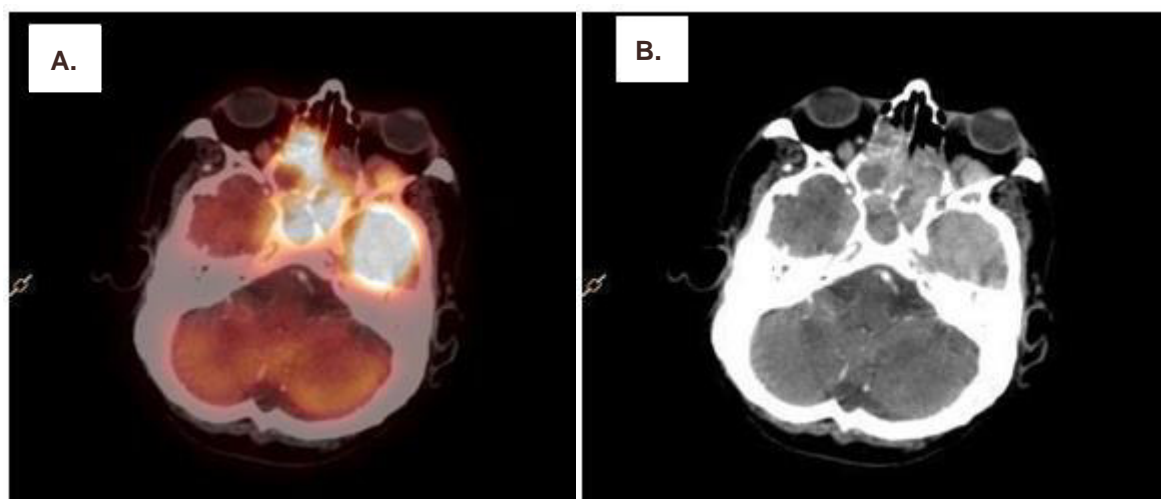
(A, B) shows the intracranial extension of the mass, which is intensely hypermetabolic, as seen on the fused PET/CT images.
